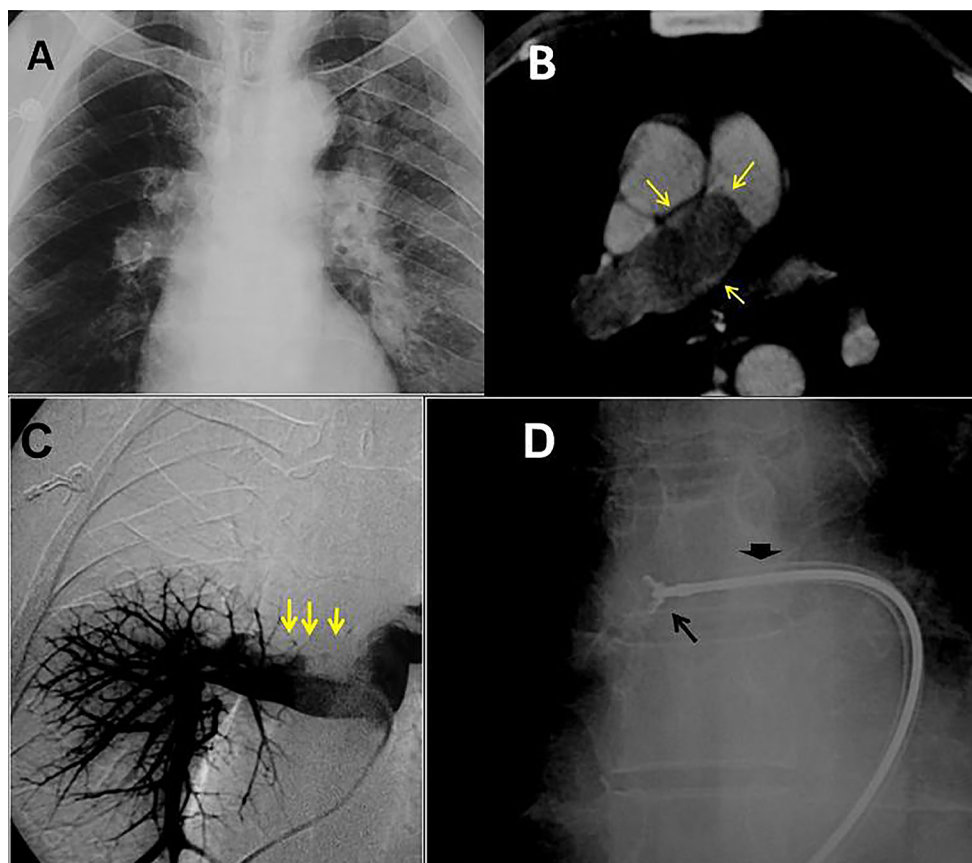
A Plain chest X-ray showing a focal peripheral hyperlucency with the absence of pulmonary vessels in the right hemithorax (Westermark sign). B Thoracic CT axial view presenting an intravascular filling defect (*arrows*) that occupies the entire lumen of right pulmonary artery. C Right pulmonary angiogram
